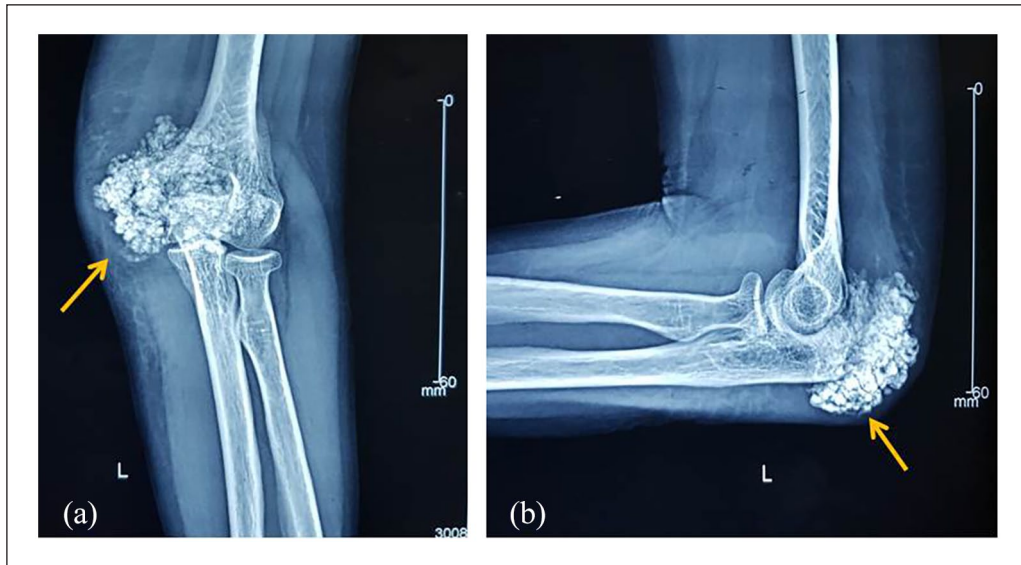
X-ray of the left elbow. (a) Antero posterior. (b) Lateral views. Orange arrow showing the deposition of radiopaque material.
